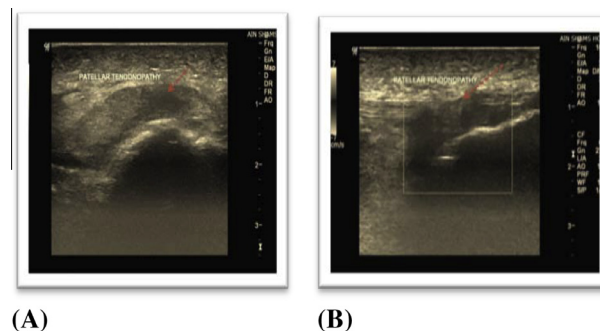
Ultrasound evaluation of distal patellar tendon in transverse (A) and longitudinal (B) view, revealed focal tendinosis (arrow) appearing as a focal area of loss of fibrillar pattern.
